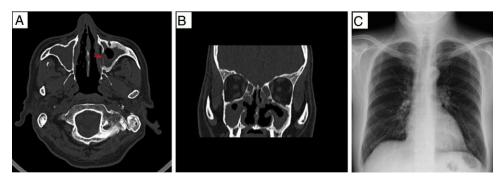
(A and B) Computed tomography images of paranasal sinuses in simple phase: axial scan (A), coronal scan (B), swollen nasal mucosa, slight bone erosion involving left maxillary antral wall (red arrow) and inferior turbinates. (C) Normal posteroanterior chest radiograph; no lesions on lung parenchyma.
